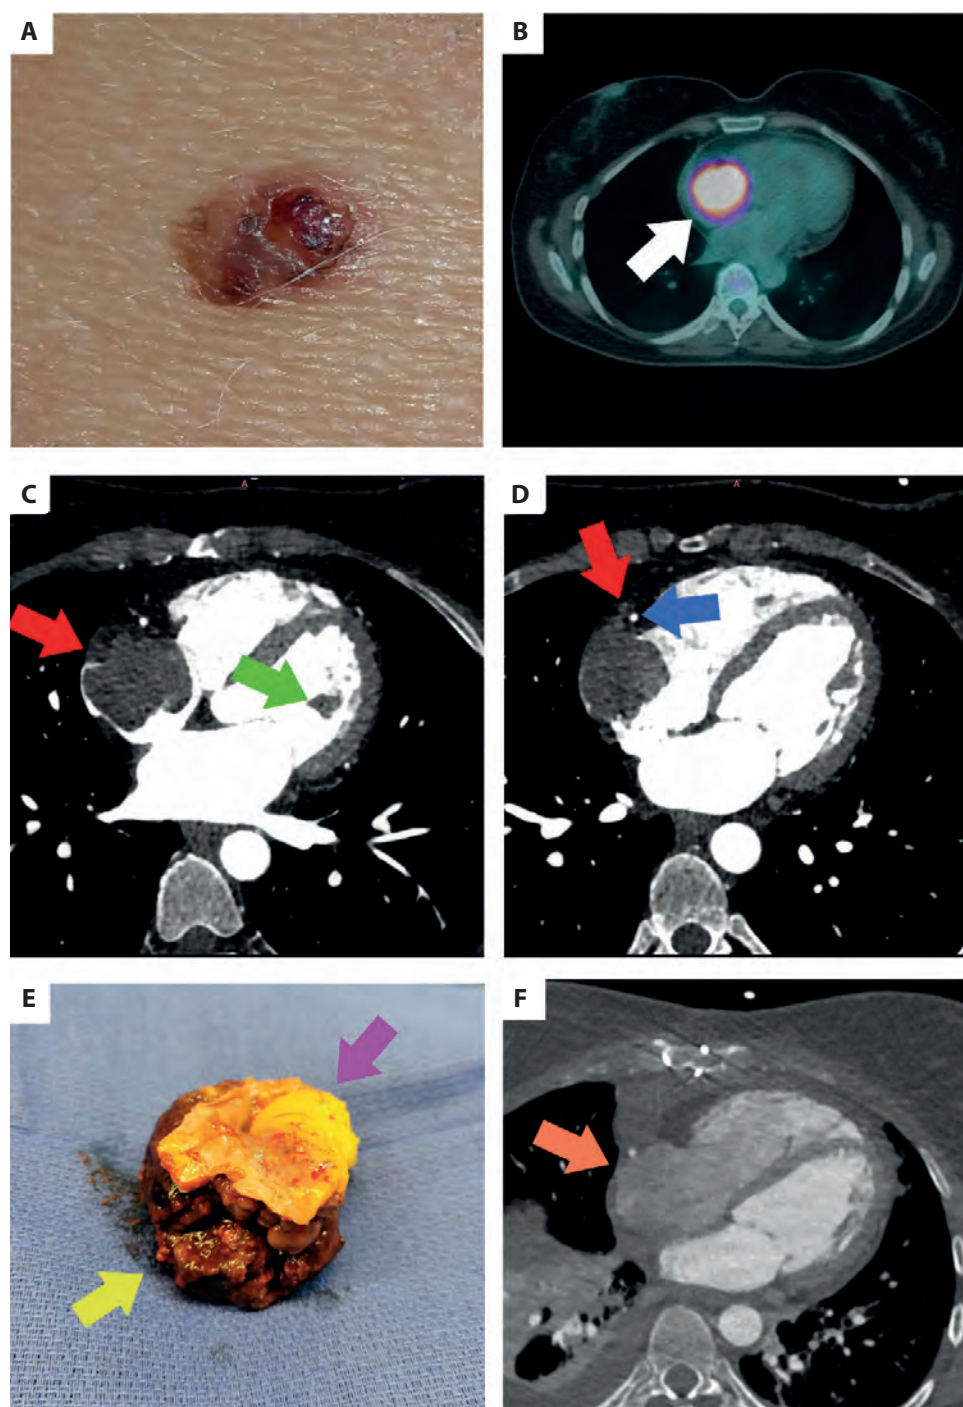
A. Initial skin lesion, excised surgically in 2015. B. 18F-FDG PET-CT scan (05.2023) with increased glucose metabolism in the right atrium (white arrow). C. and D. Contrast-enhanced CT of the heart. Red arrow points at the right coronary artery infiltration, green arrow points at the pedunculated, mobile LV mass (9×5 mm). E. Tumor after excision: tumor mass — yellow arrow, atrial wall — purple arrow. F. CT one week after surgery (orange arrow — RA)
